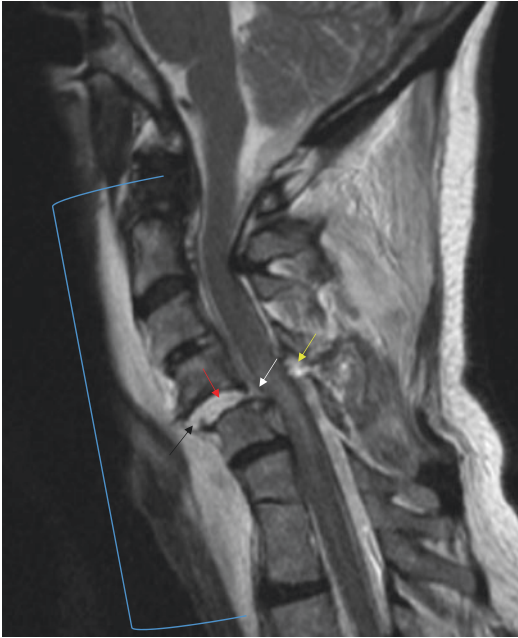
Sagittal T2-weighted image, in addition to demonstrating injury to the ALL (black arrow), demonstrates focal discontinuity of the PLL at C4-C5 compatible with complete rupture (white arrow). Note also discontinuity of the LF (yellow arrow), intradiscal injury (red arrow), and prevertebral hemorrhage (blue bracket)
